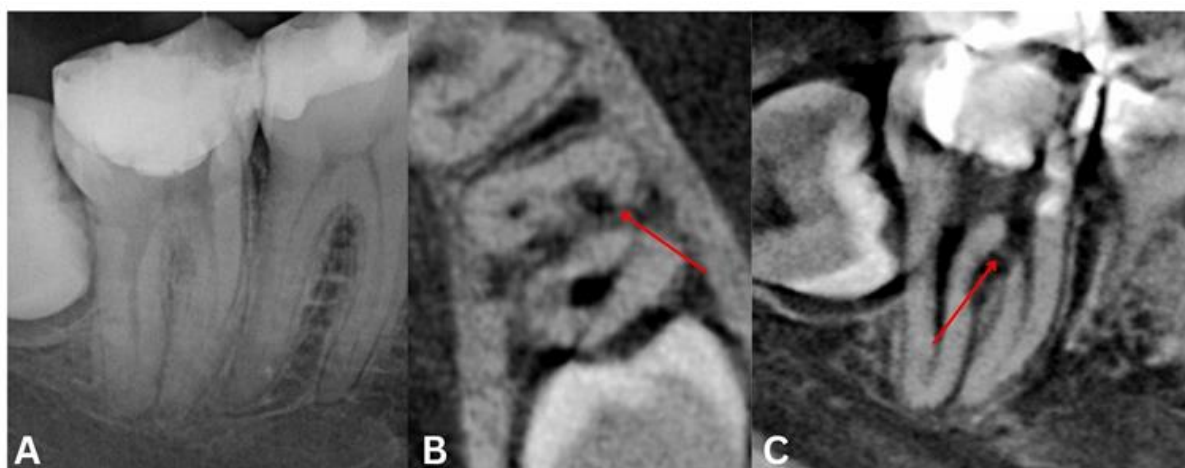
Case 1. Pre operative assessment of tooth 47. (A) The periapical x-ray showed an internal radiolucency in the mesial furcation area and a ledge on the distal canal. (B & C) The 3D imaging confirmed the presence of a perforation (red arrow) in the mesio-buccal furcation area
